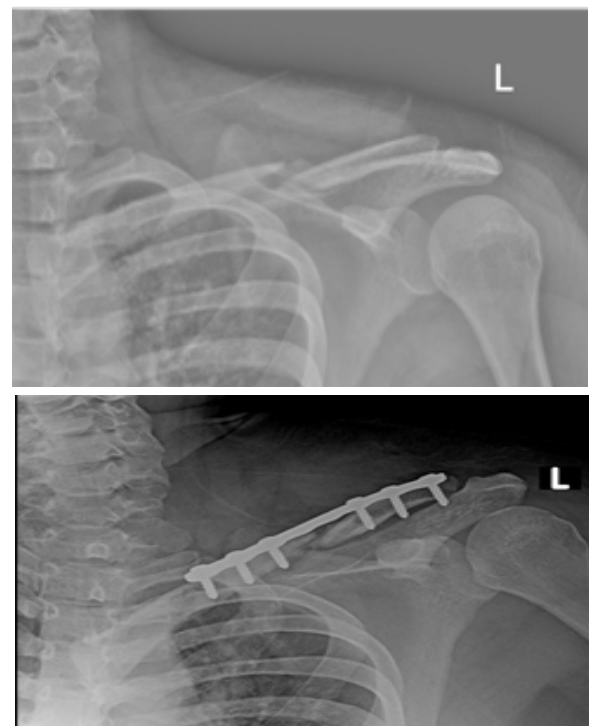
Preoperative and Postoperative Radiographs of the Left Clavicle Demonstrating Fracture Fixation
